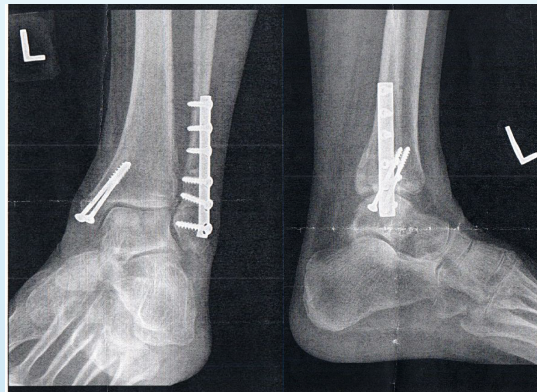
X-rays of the patient's left ankle 14 weeks post-ORIF. AP-mortise view (left picture) and lateral view (right picture).
